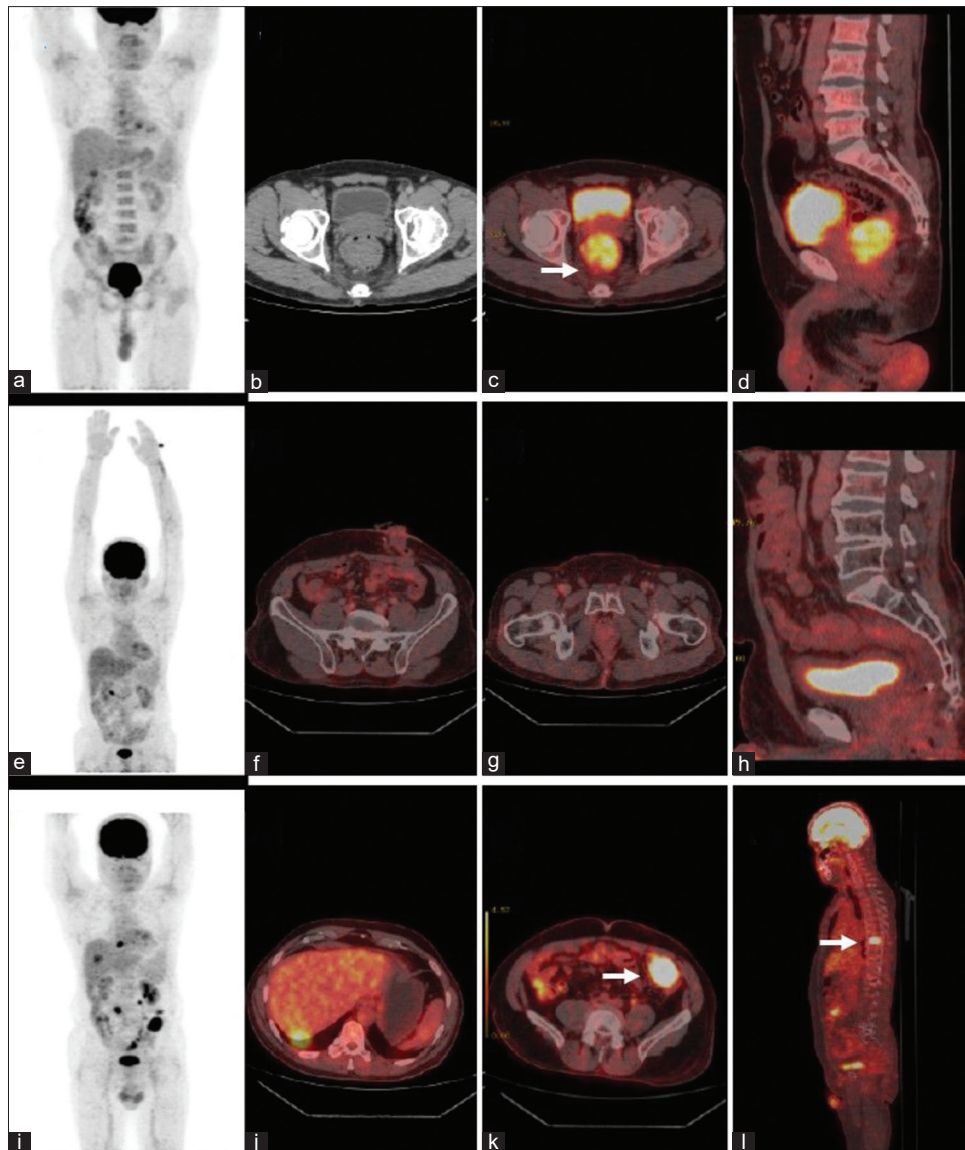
Maximal intensity projection (a) of staging whole-body fluorodeoxyglucose positron emission tomography/computed tomography scan. Axial computed tomography, fused positron emission tomography/computed tomography, and sagittal-fused positron emission tomography/computed tomography (b-d) images showing fluorodeoxyglucose-avid intraluminal mass lesion in anorectum region. MIP (e) of follow-up positron emission tomography/computed tomography scan after 6 months. Fused positron emission tomography/computed tomography axial and sagittal views (e-h) suggestive of an absence of fluorodeoxyglucose-avid visible mitotic disease. Maximal intensity projection (i) of positron emission tomography/computed tomography scan done 10 months after staging. Fused positron emission tomography/computed tomography axial and sagittal images (j-l) suggestive of recurrence with fluorodeoxyglucose-avid metastatic lesions in the liver, abdominal deposits, and fluorodeoxyglucose-avid skeletal lesion
